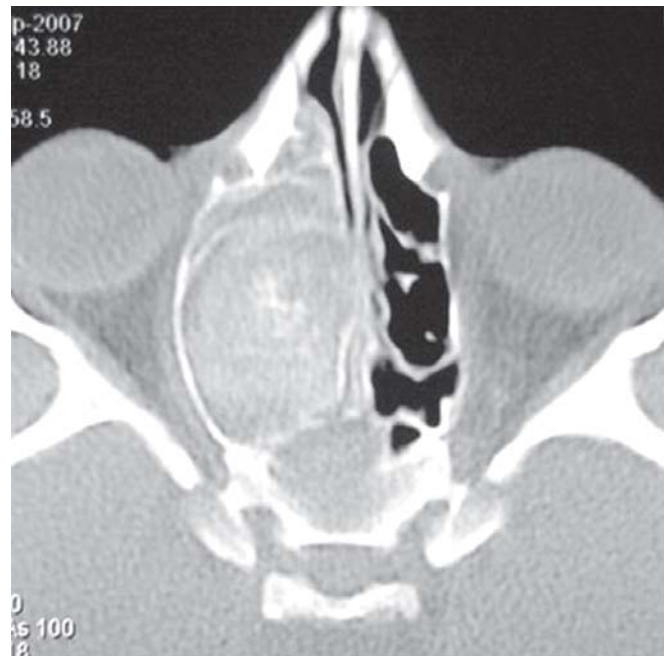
Axial CT – PNS showing expansion of the right sinonasal compartment with corresponding compromise of the right orbital volume, with remodelling of the right lamina papyracea, as compared to the left side, in a case with right sided AFRS
